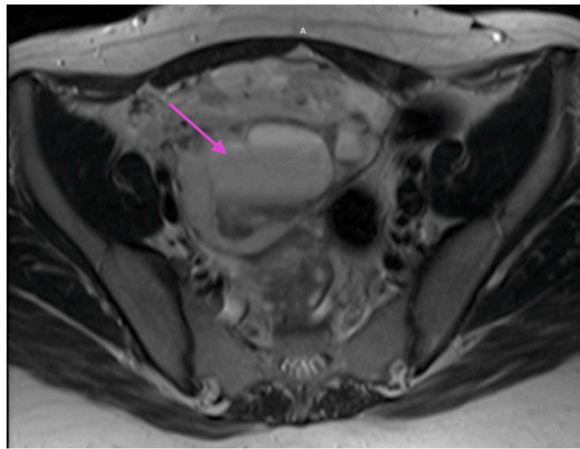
MRI image at time of diagnosis. Arrow indicating multiple fluid levels present within the mass.
